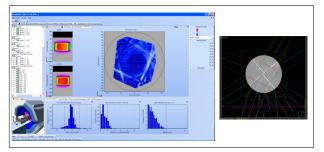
Measurement compared to calculations for the Simple Model. Scan of DELTA4 with the CT table model (bright lines represent the detector planes, density overwritten in TPS)
